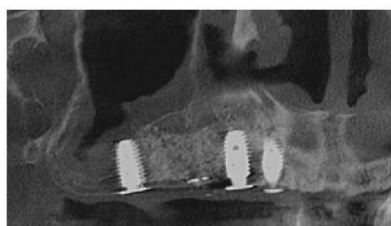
Five-month postoperative CBCT evaluation.
